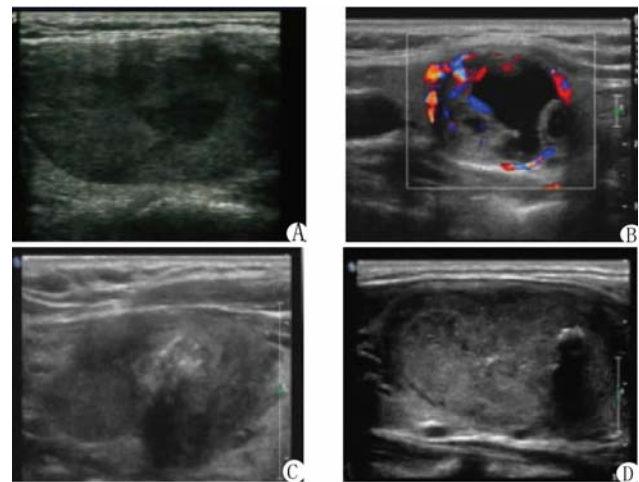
Ultra sonogram of MTC
